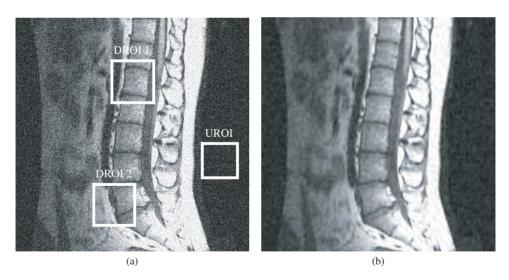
Experiments on MRI image *Spine*. The Desired Region Of Interest (DROI) and Undesired Region Of Interest (UROI) used to compute the MSR and CNR indexes (listed in Table 6) are highlighted. (a) The noisy image. (b) Estimated by the STH. (c) Estimated by the HTH. (d) Estimated by the presented MPTH.
